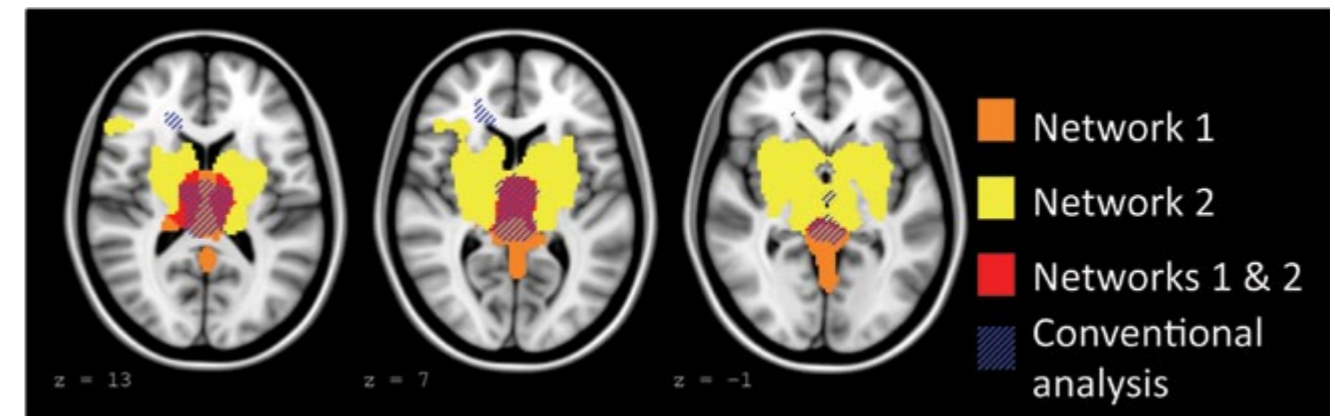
Two of the six functionally distinct networks associated with abnormal brain activity in Absence epilepsy are shown in yellow and orange (and red where they overlap), overlaid upon three axial MRI slices. Our new analysis approach provides evidence for activation in a much larger network of brain regions than seen using conventional model-based analysis (blue hatched region).
